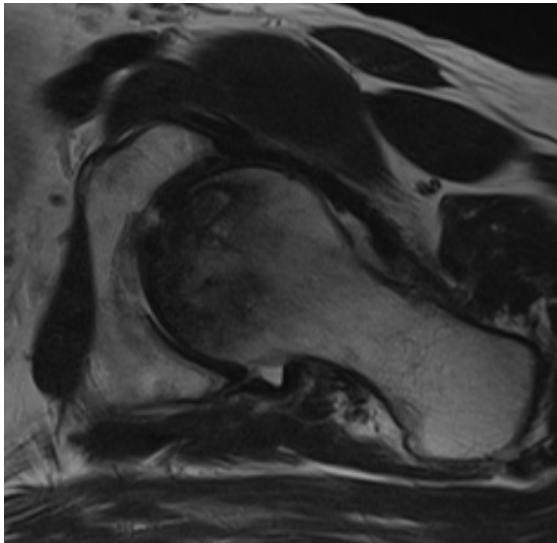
MRI of the hip that shows avascular necrosis
